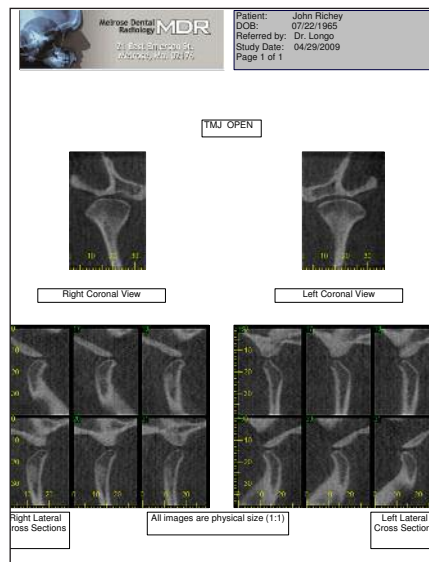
The initial cone beam scan demonstrated that the condyles had been reduced along the posterior superior surfaces, and the posterior surfaces of the condyles showed signs of flattening and sclerosis, and signs of regressive remodeling through function.
